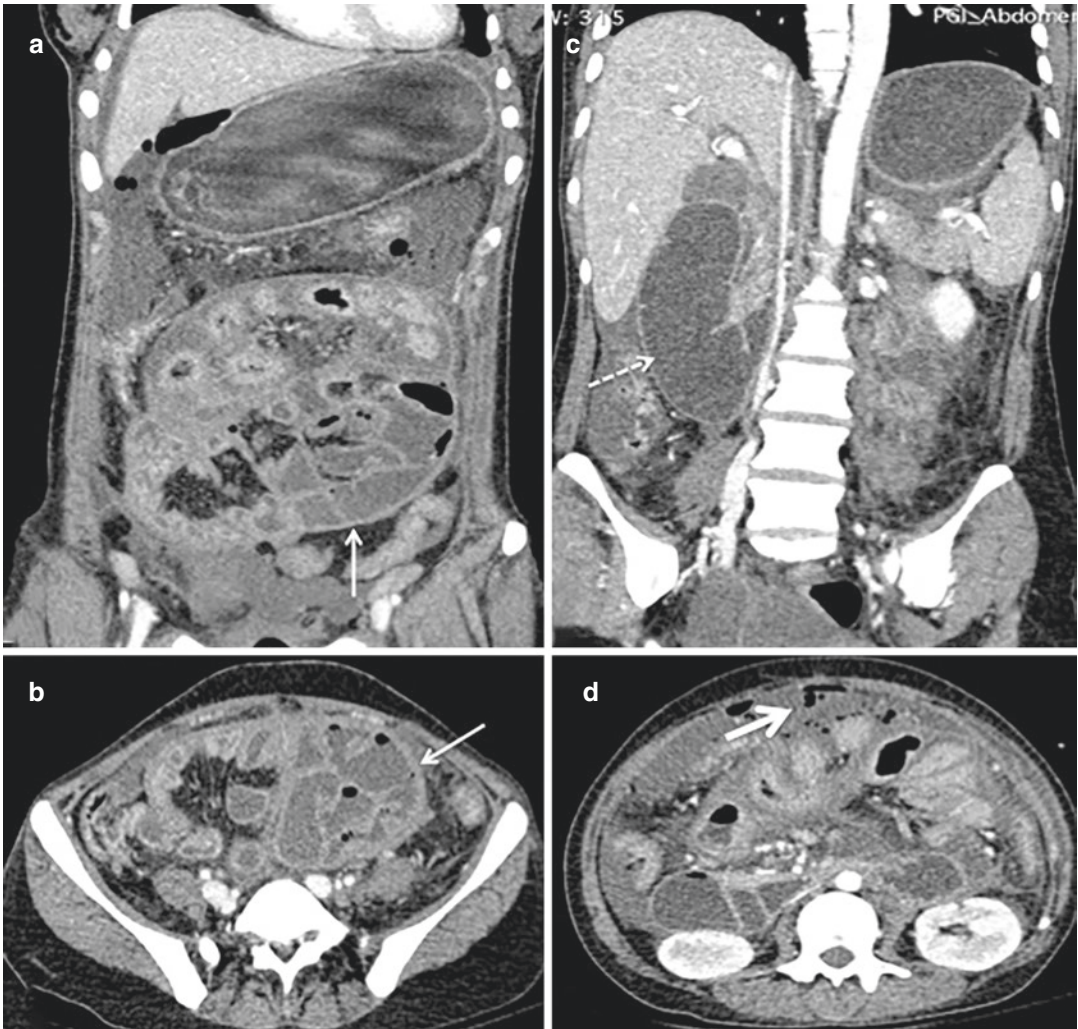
31-year-old woman, a known case of abdominal tuberculosis on anti-tuberculosis treatment, who presented with abdominal distension and nonpassage of stools. (a) Coronal and (b) axial contrast-enhanced CT images show peritoneal thickening and “cocoon” (sclerosing encapsulating peritonitis) formation (thin solid arrows), leading to encapsulation of jejunal and ileal
